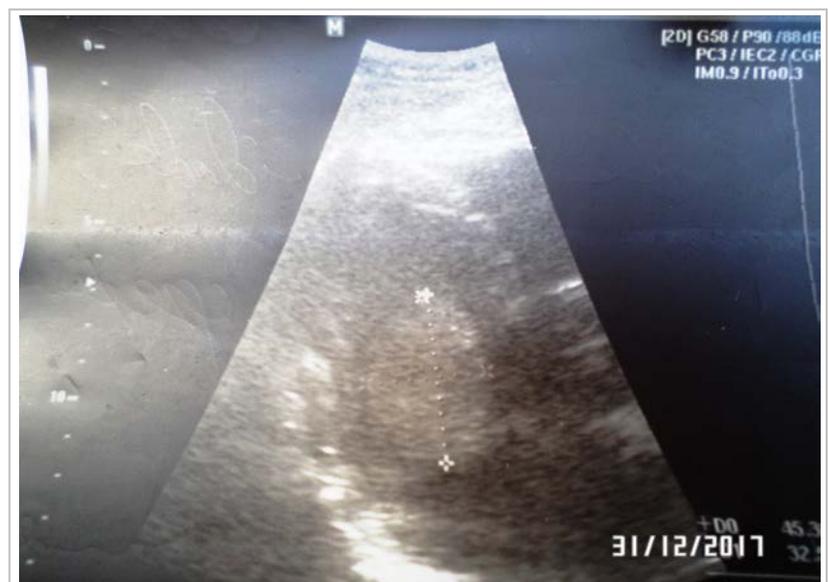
Transthoracic echocardiogram performed at the provincial hospital, where an intracardiac mass of 45 × 32 mm, diastolic protruding into the left ventricle is observed.
